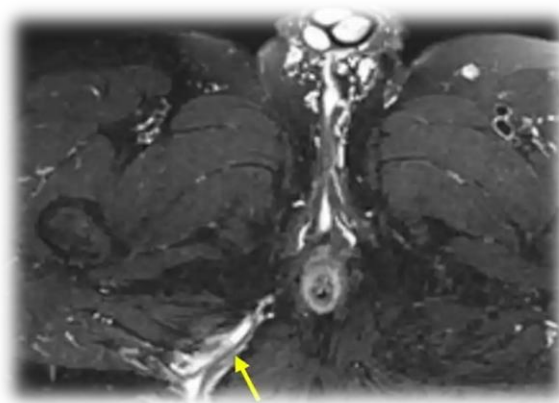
Pelvic MRI for Right Intersphincteric anal fistula.
